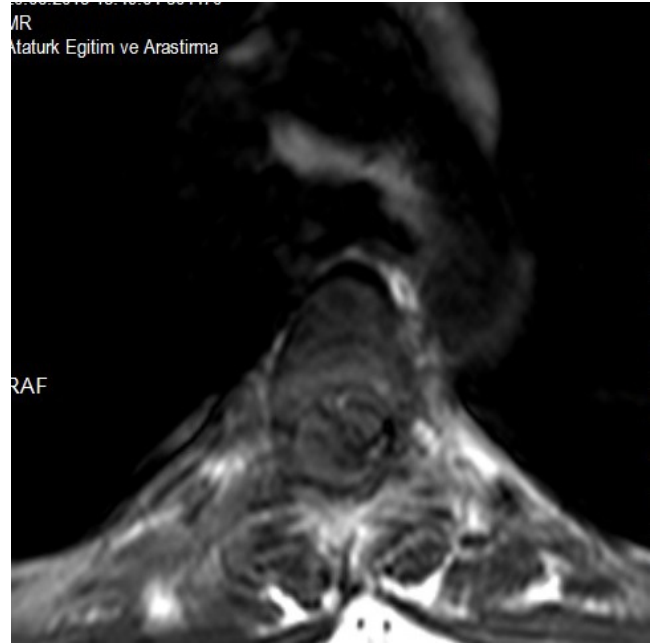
Axial MRI section showing epidural mass with cord compression at T4-T6 level.
